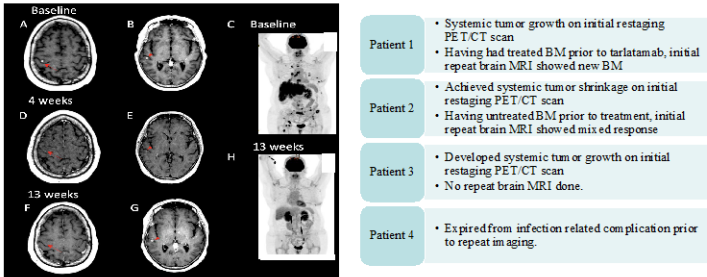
Initial intracranial response based on repeat brain MRI following tarlatamab: A. For patients who had radiographic evidence of untreated BM prior to treatment. B. For patients who either had no BM prior to treatment, or who had treated BM prior to tarlatamab.
